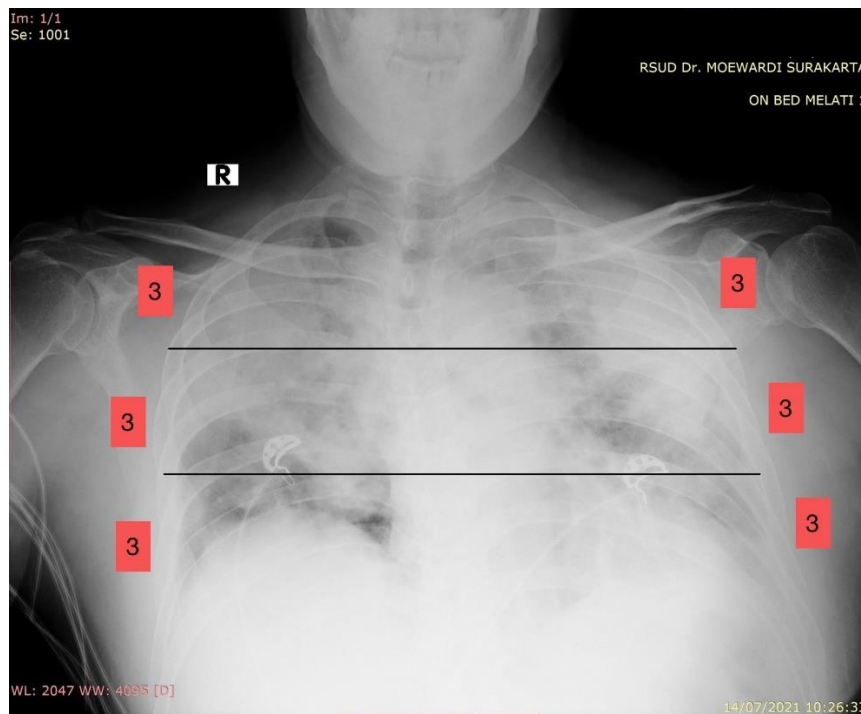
Chest x-ray of patient died with severe category of Brixia Score
